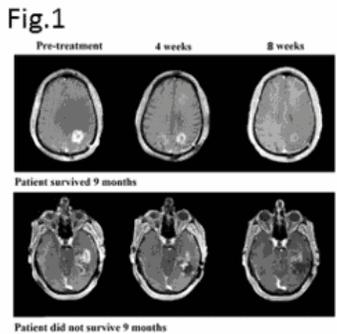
It is challenging to distinguish tumor response and pseudo-response on T1 weighted post contrast MR images. Both patients show a marked reduction in contrast enhancement.
